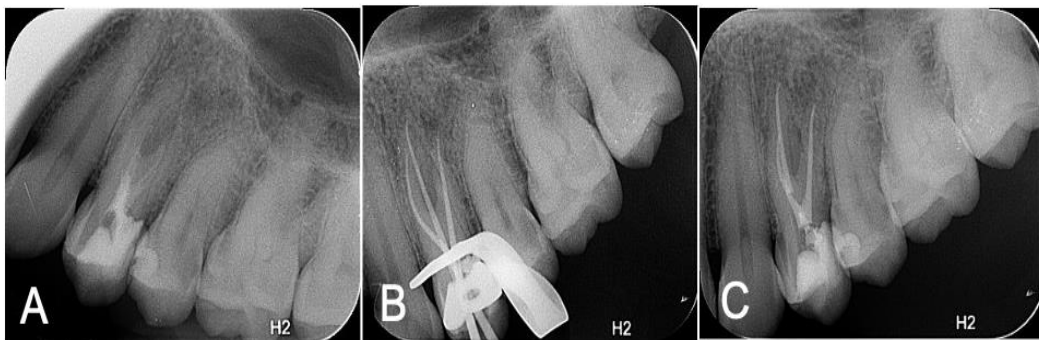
#24: (A) Preoperative periapical radiograph with old GP; (B) periapical radiograph with GP removed and master cones placed confirming presence of three canals; (C) periapical radiograph showing final obturation.
